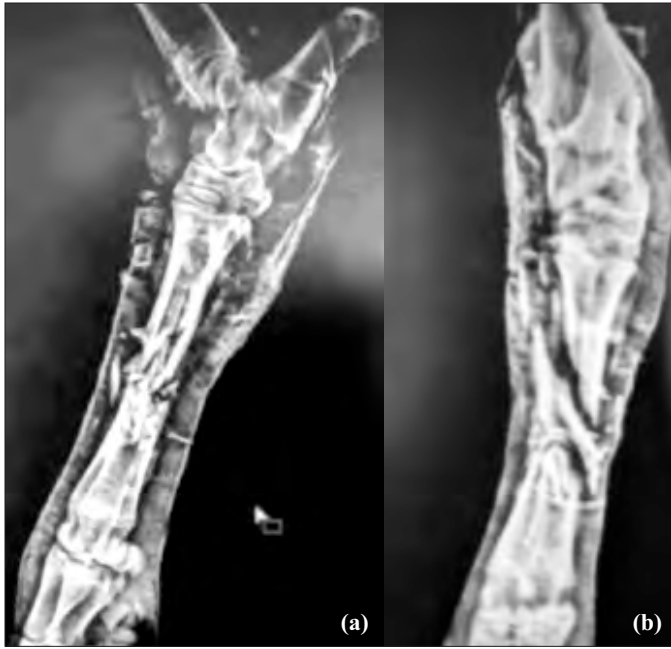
L/M (a) and D/planter (b) views of left metatarsal bone showing midshaft compound comminuted fracture. Synthetic cast is visible on the radiograph
